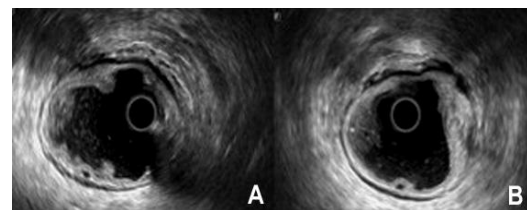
Endorectal ultrasound. Thickening of the rectal folds with ulceration affecting the mucosa and submucosa, sparing the muscularis propria. Absence of lymphadenopathy in the mesorectum.
